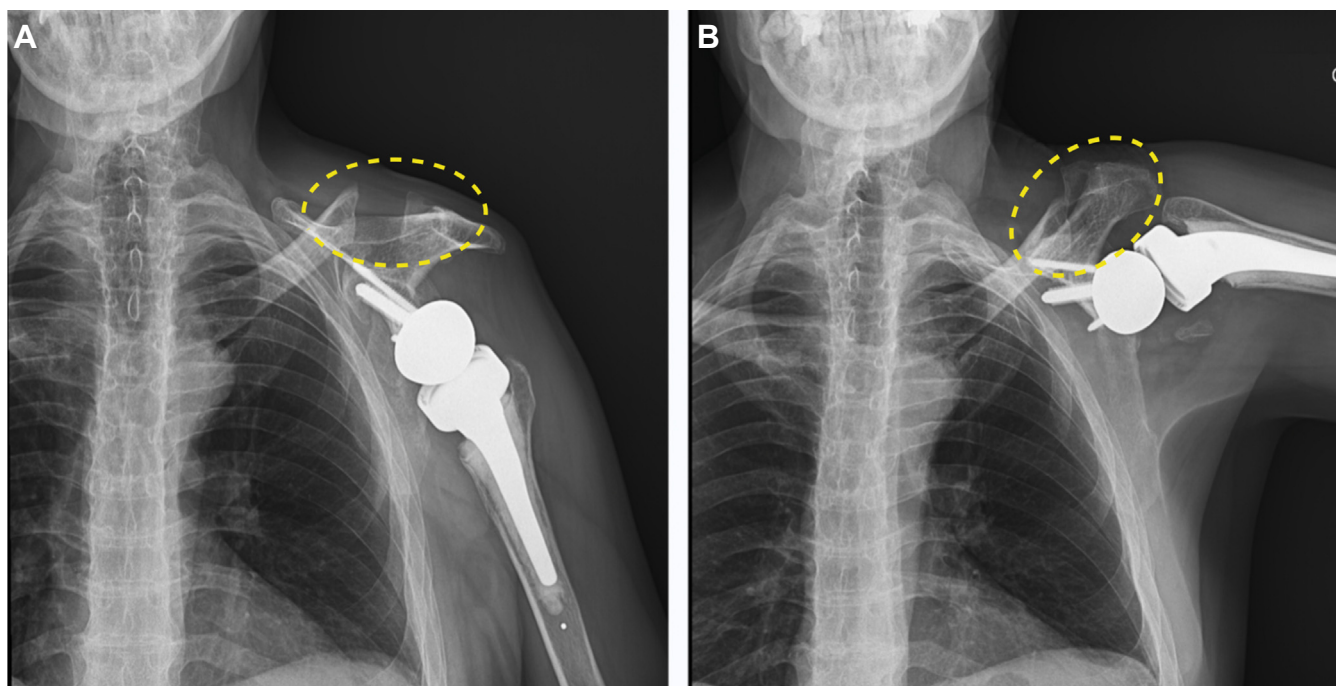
Anteroposterior resting (A) and dynamic (B) abduction radiographs after revision reverse shoulder arthroplasty and releasing osteotomies of the scapula show improved scapular motion, which is indicated by the screws fixing the baseplate in the scapula and the closure of the acromioclavicular gap after resection (○). The scapula is moving around a disconnected clavicle, which remains in a static position.
